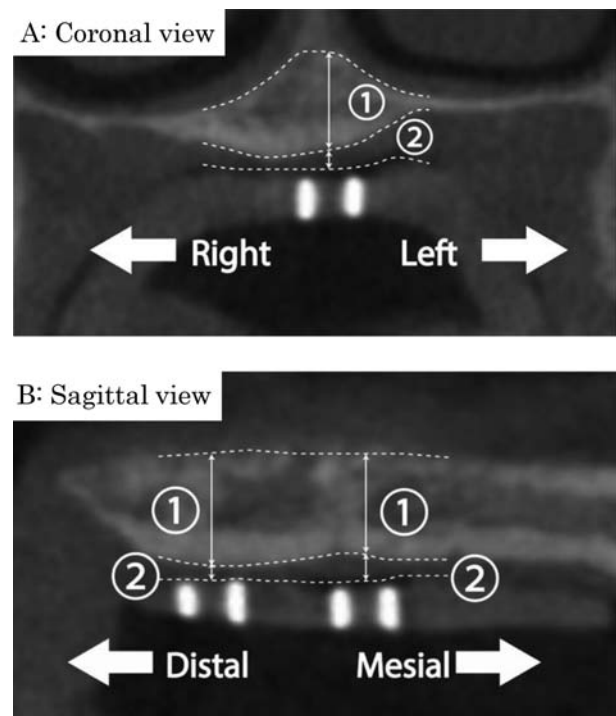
CBCT images when a surgical guide stent for implantation was placed while measuring the thickness of palatal bone and mucosa
